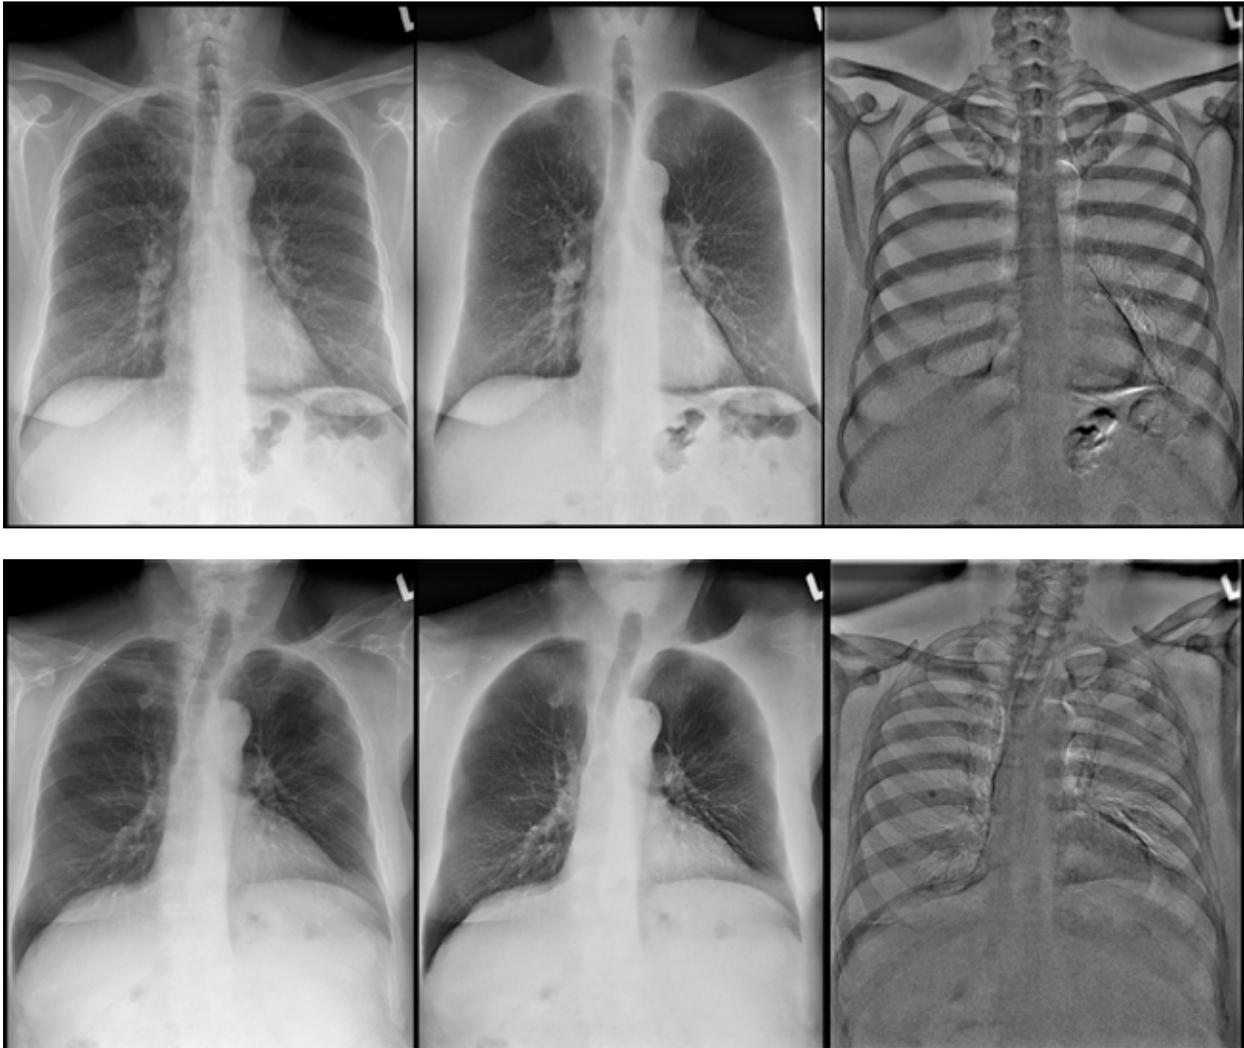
Two sets of image examples comparing between standard radiography (on left), and the soft tissue (in middle) and bone (on right) images from dual energy subtraction.
